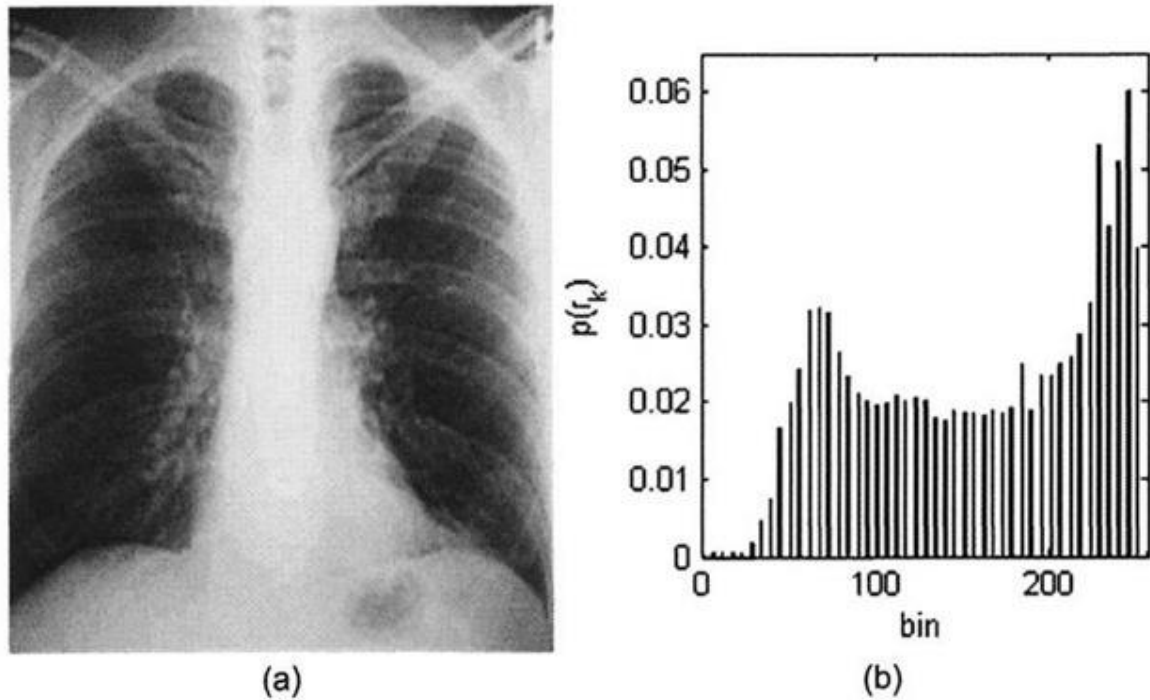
(a) Contrast-stretched chest x-ray image, (b) Modified histogram [24]
